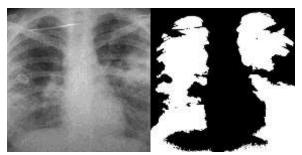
Image processing result for sample of TB X-Ray lung image.
